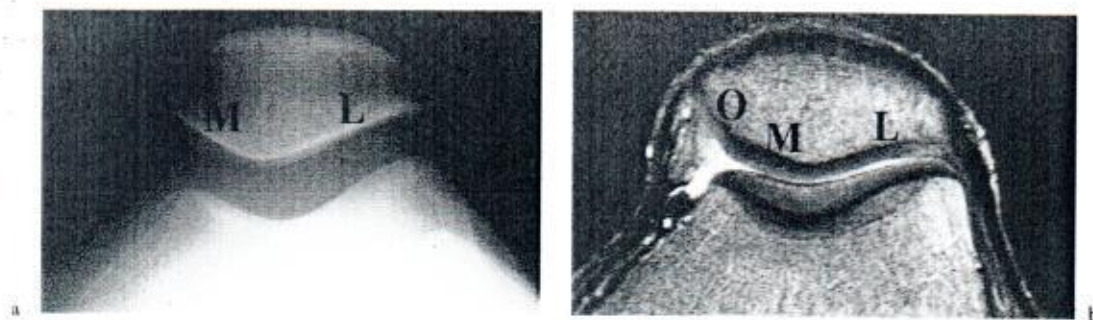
Normal patellofemoral joint in a 24-year-old male. a Axial radiographic view and b transaxial MR sectioning through the middle of the patella obtained by a proton fat-saturated sequence with the knee in 20° of flexion. The lateral (L) facets of the patella and the femoral condyle are larger than the medial facets (M), and the depth of the osseous condylar groove is greater than the cartilaginous. The medial patellar cartilaginous facet is separated from the odd facet (O) by a ridge
